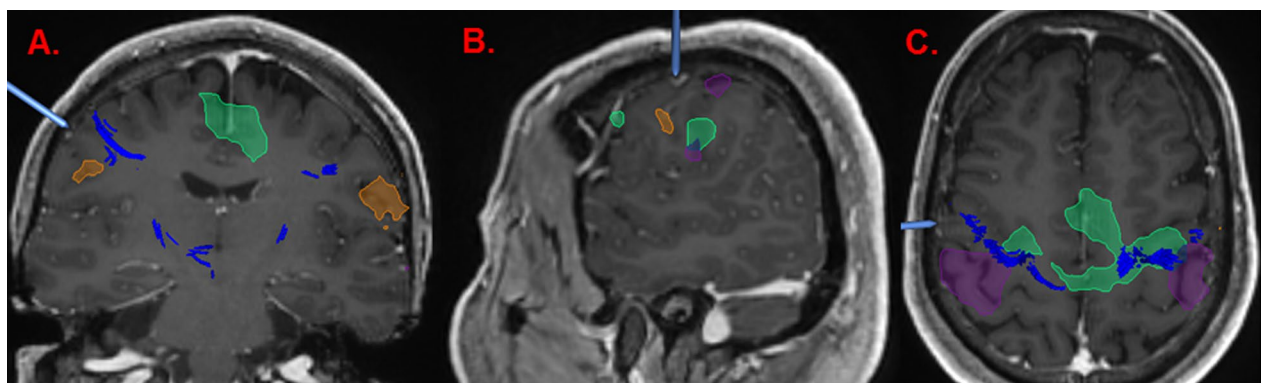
Preoperative functional MRI. Green = foot, purple = hand, orange = tongue: A coronal, B sagittal, C axial
